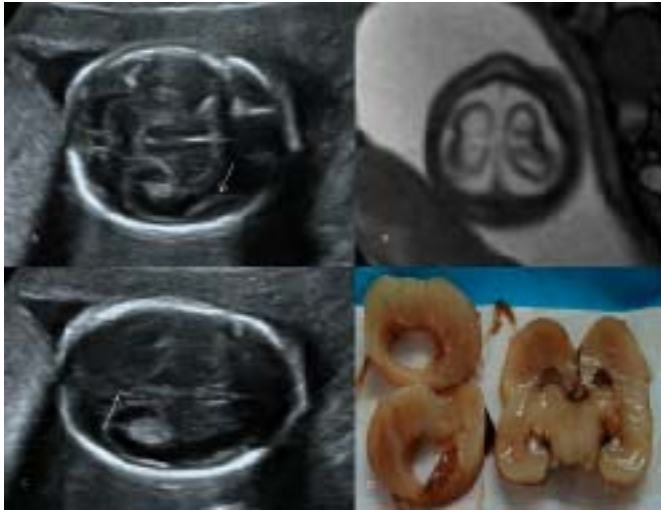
Transverse ultrasonographic view of the fetal brain at 26 weeks showing smooth Sylvian fossa (arrow). B: Transverse ultrasonographic view of the fetal brain at 26 weeks showing absent parieto-occipital sulcus (arrow) development. C: Axial T2-weighted b-TFE image through the level of lateral ventricles. The gyri and sulci of the cerebrum are highly premature with respect to the age of the fetus. D: Postmortem examination of fetal brain showing complete absence of cortical sulci, and gyria at coronal sections.
